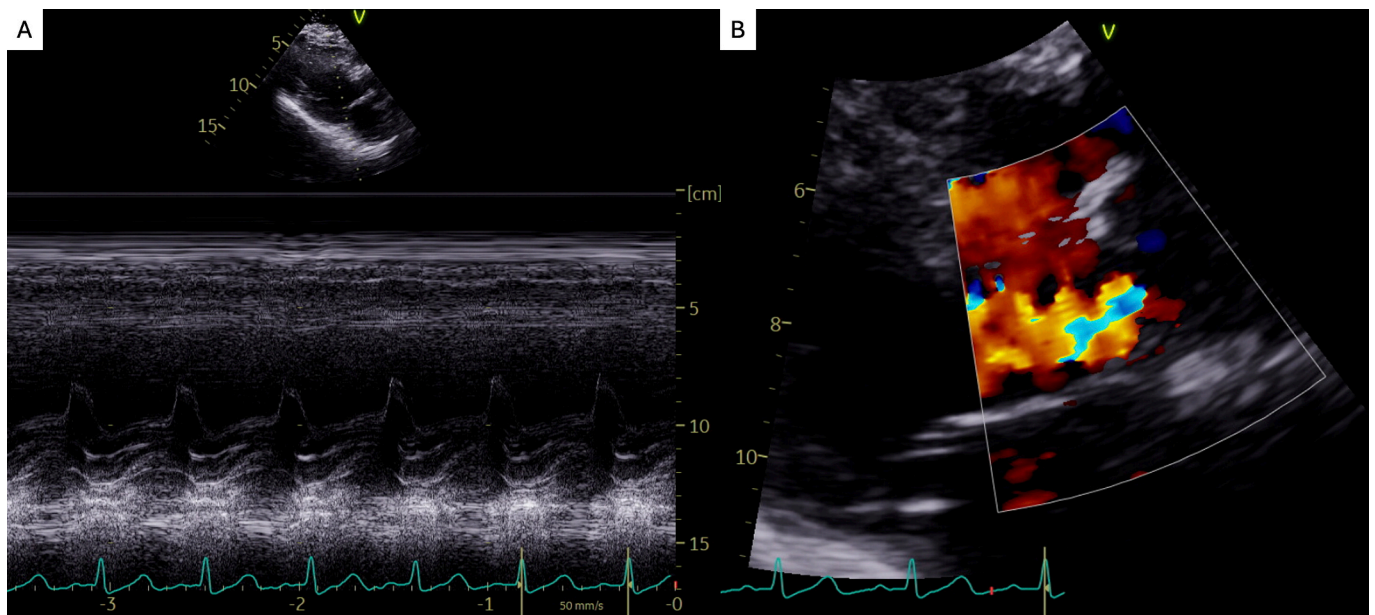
Transthoracic echocardiogram. (A) Parasternal long-axis view revealing E-point septal separation suggestive of preserved ejection fraction. (B) Parasternal long-axis view revealing moderate aortic regurgitation.
